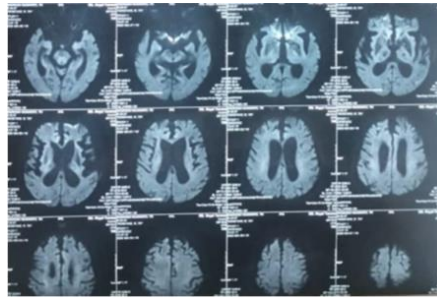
MRI Brain Axial DWI. There is No Sign of Water Restricted Area (There is No New Infarct)
